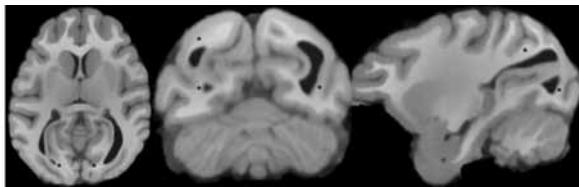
Enlarged occipital horns (colpocephaly) on MRI. Axial, coronal, and sagittal slices of a 3D, T1-weighted MRI study depicting elongated, eccentrically enlarged occipital horns. Black asterisks indicate the occipital horns.
